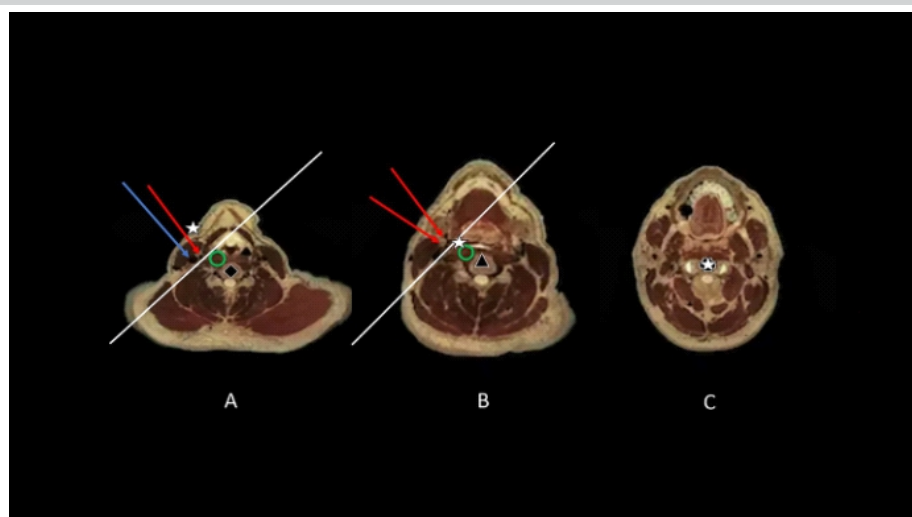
Anatomical mapping and trajectory planning of the novel anterolateral percutaneous approach to C2: Axial computed tomography cadaveric images labeled to demonstrate a novel percutaneous approach to C2. Skin entry site (a) at C5 (diamond), caudal to the carotid bifurcation. The skin entry site (star) is medial to the common carotid artery (red arrow) and jugular vein (blue arrow) and anterolateral to the midline spine. The angle of entry is cephalad and medial toward the longus colli muscle (green circle). The plane medial to the vessels must be reached before the level of the carotid bifurcation to avoid small branches not visible with ultrasound. Axial level (b) at the level of the carotid bifurcation (red arrows) demonstrates that the needle tip (star) is medial to the vessels at this point – approximately C4 (triangle). From here until the target the only structure left to traverse is the longus colli muscle (green circle). Axial image (c) at the level of C2 (cross) demonstrating needle deep to longus colli at target (star). Images used with permission (Micheau A, Hoa D, e-Anatomy, www.imaio.com, DOI: 10.37019/e-anatomy).
